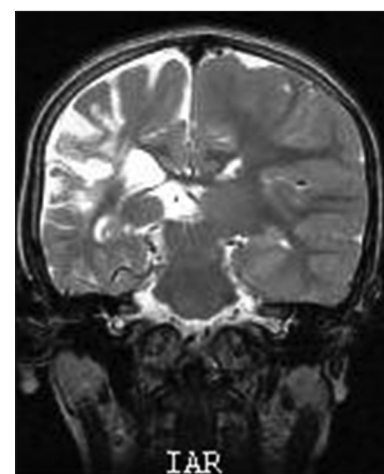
MRI showing diffuse hemispherical atrophy with hyperdense signals on right side
